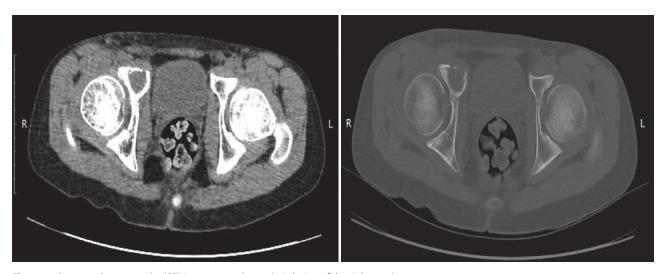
Computed tomography (CT) images reveal osteolytic lesion of the right cotyle.
